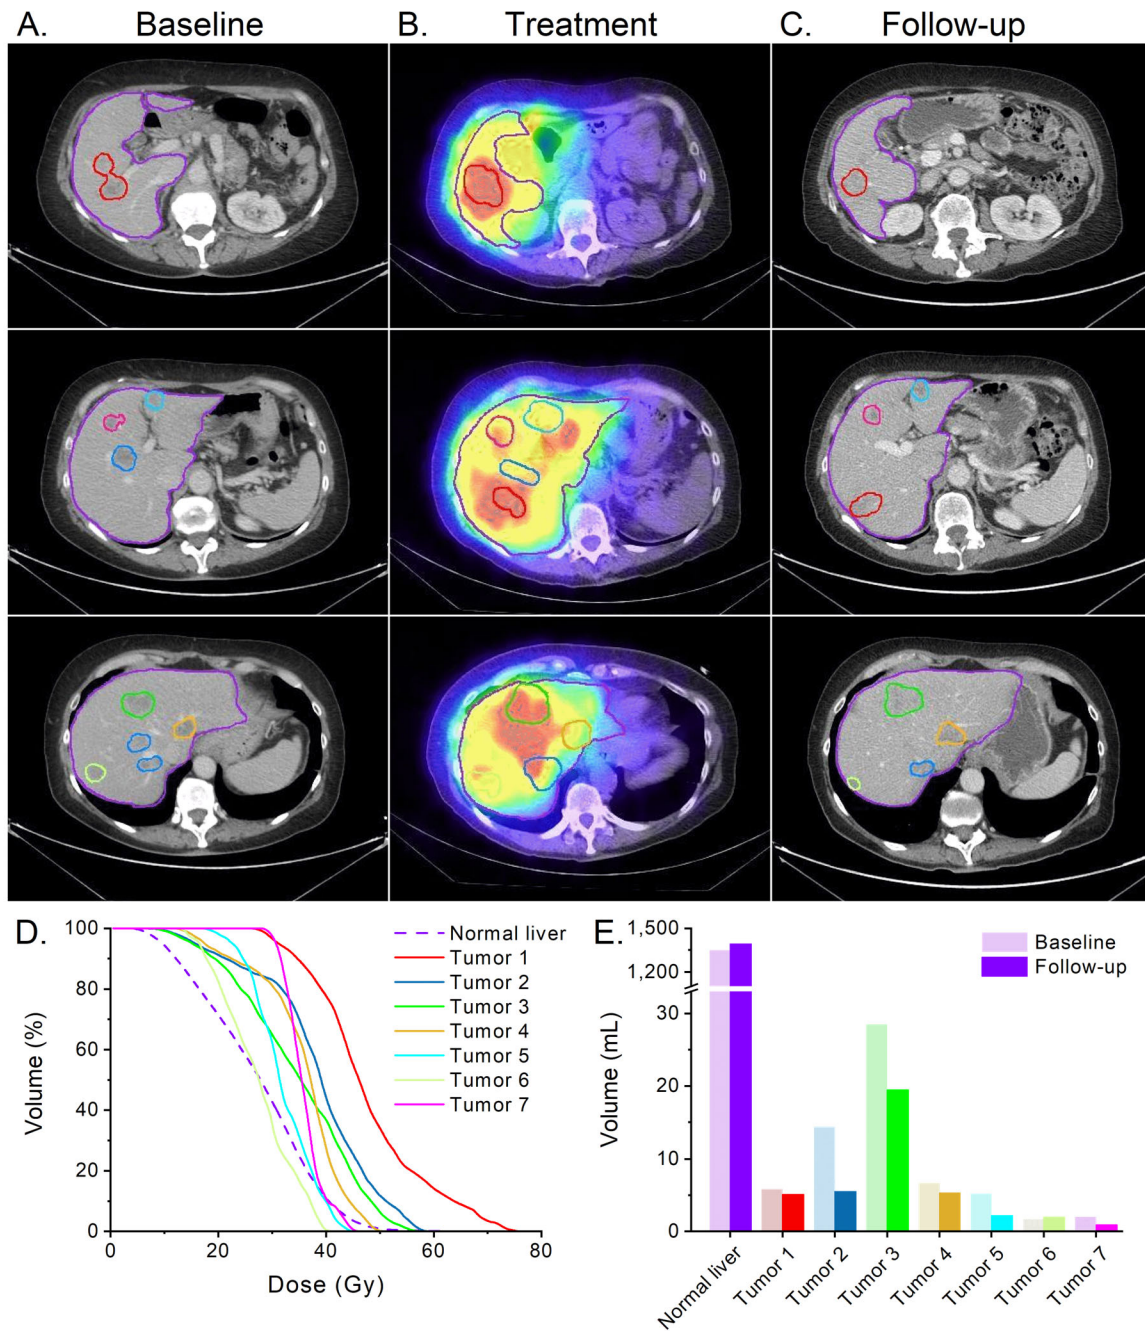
Patient 14 (66y, 1.70m² BSA): liver, ovarian, and pulmonary metastases, treated by resection of descending/sigmoid colon adenocarcinoma and three courses of chemotherapy. (A) Baseline CT acquired 27-days before SIRT. ^{99m}Tc-MAA, angiography and coil embolization were performed, achieving 0% lung shunt. ⁹⁰Y microspheres were administered in two injections of 939 MBq, (B) SPECT/CT 1-day post-SIRT demonstrated variable accumulation in tumors. (C) CT at 74-days revealed
